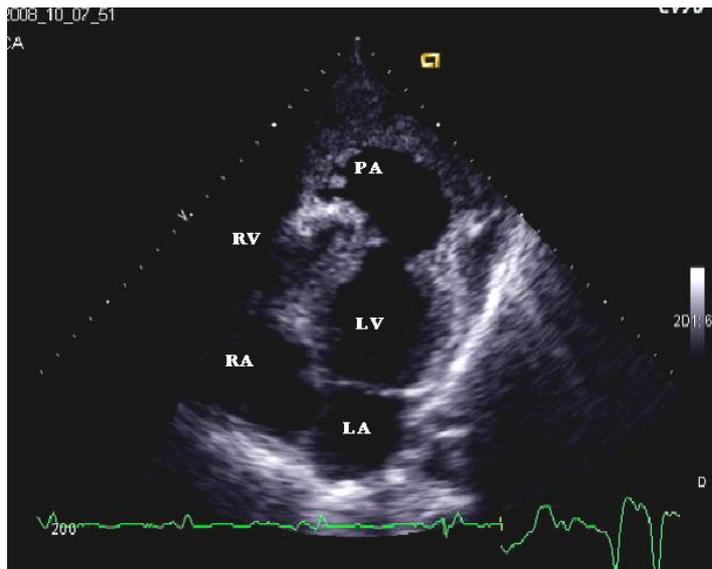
Transthoracic echocardiography of a 59-year-old man, who presented to the emergency department with dyspnea and lower extremity edema, in the four-chamber view. Huge apical pseudo-aneurysm of the left ventricle filled with thrombosis is evident. LA: left atrium, LV: left ventricle, PA: pseudo-aneurysm, RA: right atrium, RV: right ventricle.
